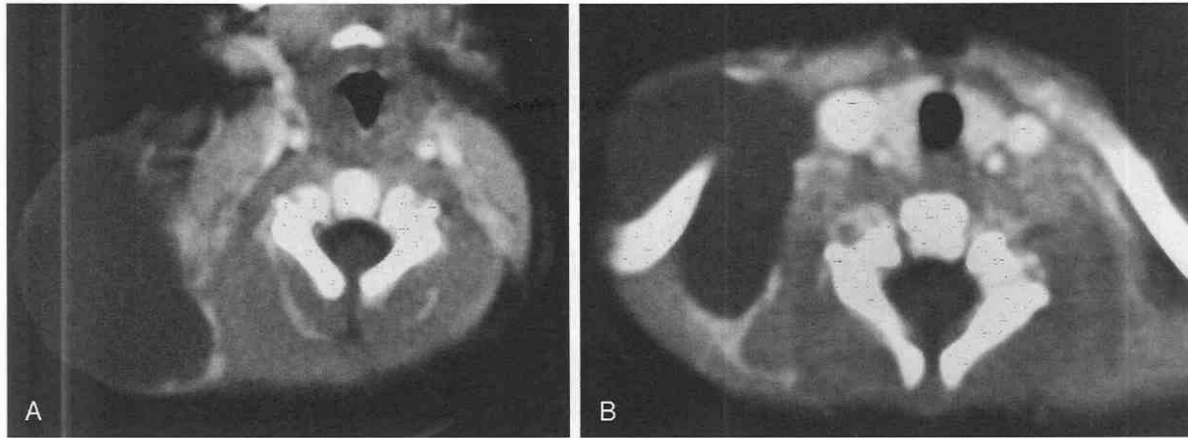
Lymphatic malformation (cystic hygroma). Axial postcontrast CT scan. *A* and *B*, A large, nonenhancing mass of decreased attenuation is present off the lateral aspect of the right neck with extension to the area of the thoracic inlet. Minimal peripheral enhancement is present.
